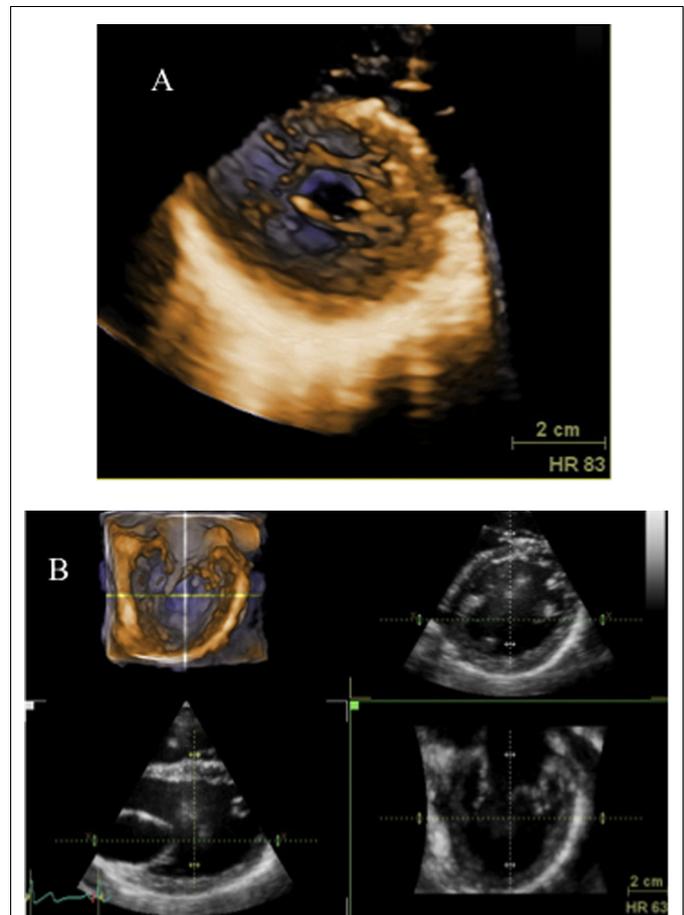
Three-dimensional echocardiography showed the trabecular meshwork on short-axis view (A). Each orifice had a subvalvular apparatus (B).
